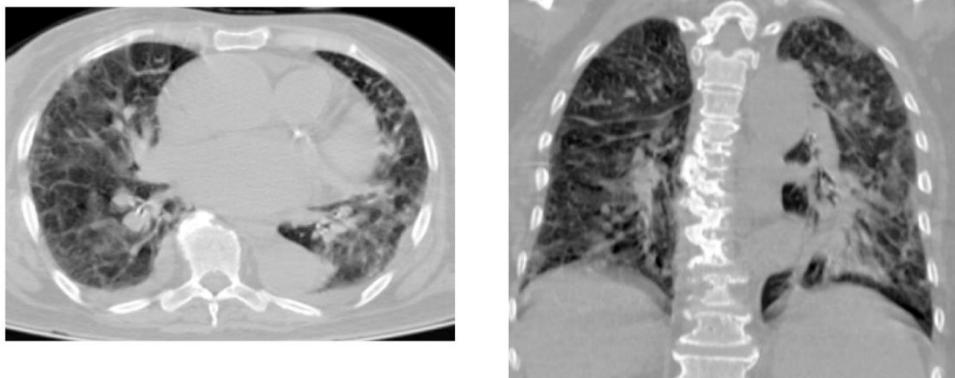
High resolution computed tomographic images ,axial sections and coronal reconstruction images shows bilateral multilobar areas of diffuse ground glass opacities with ill-defined pattern of distribution. Areas of consolidation are noted in the left lower lobe (thick white arrow). Both lungs show interstitial septal thickening with bronchial wall thickening. Bilateral minimal pleural effusion. No lymphadenopathy. Note: Tortuous descending aorta and anterior osteophytes of the spine (white thin dashed arrows).
